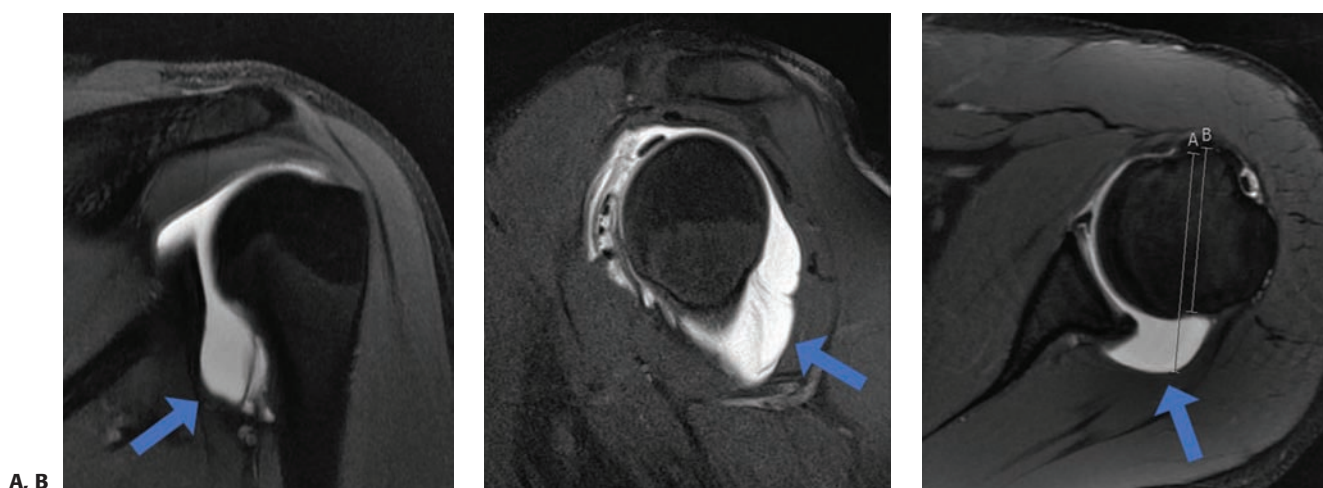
A: Coronal T2-weighted MRA image shows patulous inferior capsule (arrow) in a patient with MDI. B: Sagittal oblique T2 MRA also confirms the enlarged capsule (arrow). C: Axial T2 MRA image demonstrates increased posterior capsule volume (arrow) without any evidence of posterior labral tear in this patient with MDI.
